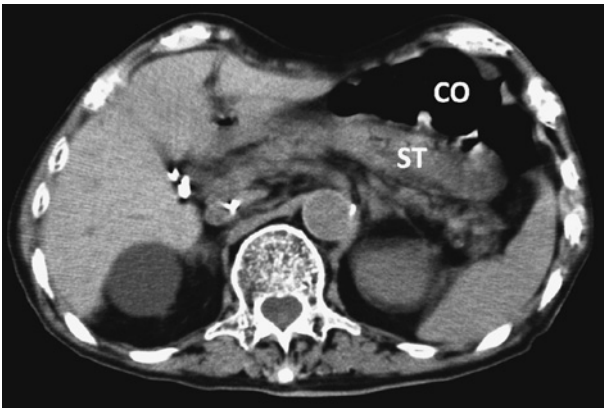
CT image before gastrostomy.
